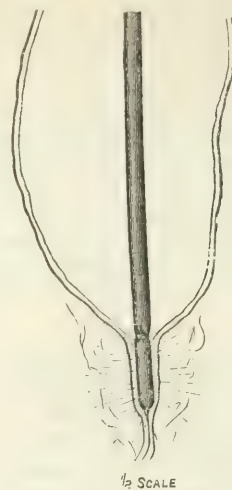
Showing radium tube in position of maximum efficiency in strictured malignant gullet, inserted through œsophagoscope and position checked by the X-ray screen.
